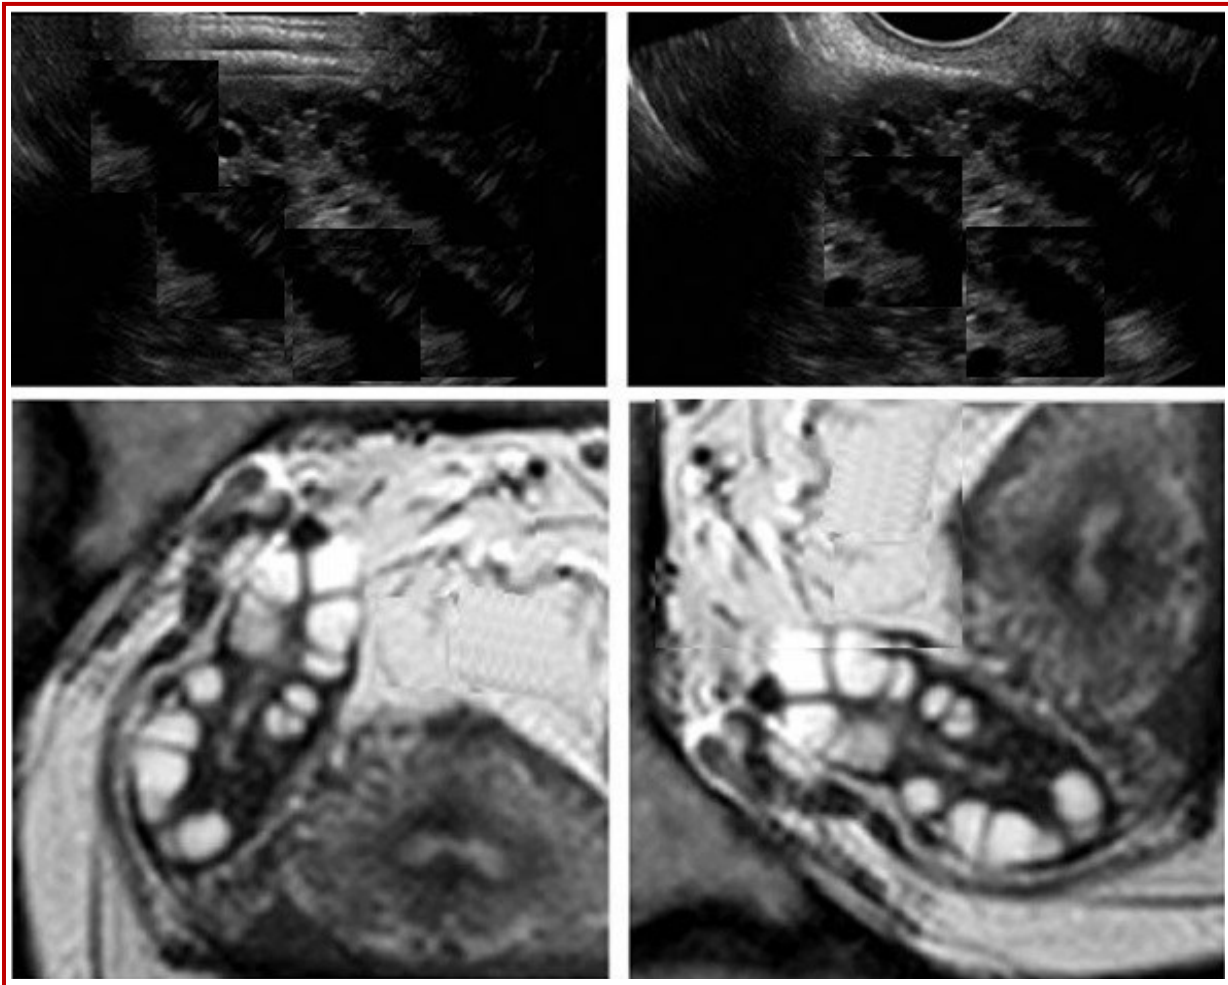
Ultrasonography of patients with polycystic ovary syndrome
